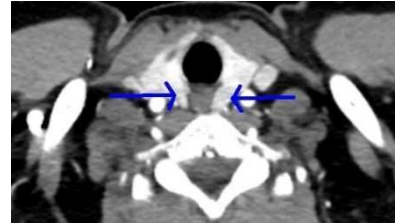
CT scan with contrast injection at arterial time showing parathyroid nodules in bilateral paraesophageal position.
